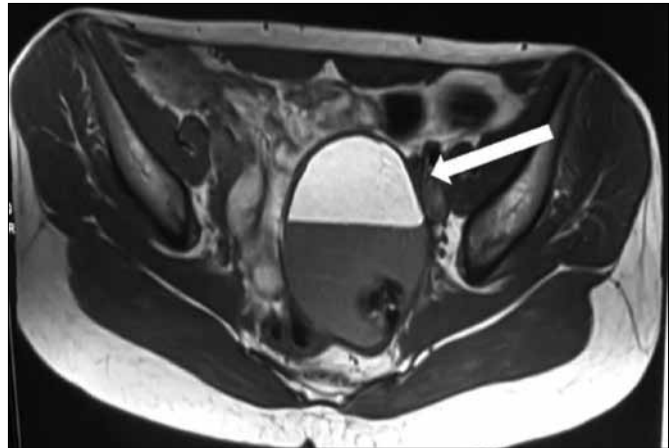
Axial T1-weighted image MRI demonstrates a pelvic cystic structure containing fat (indicated by arrow)
